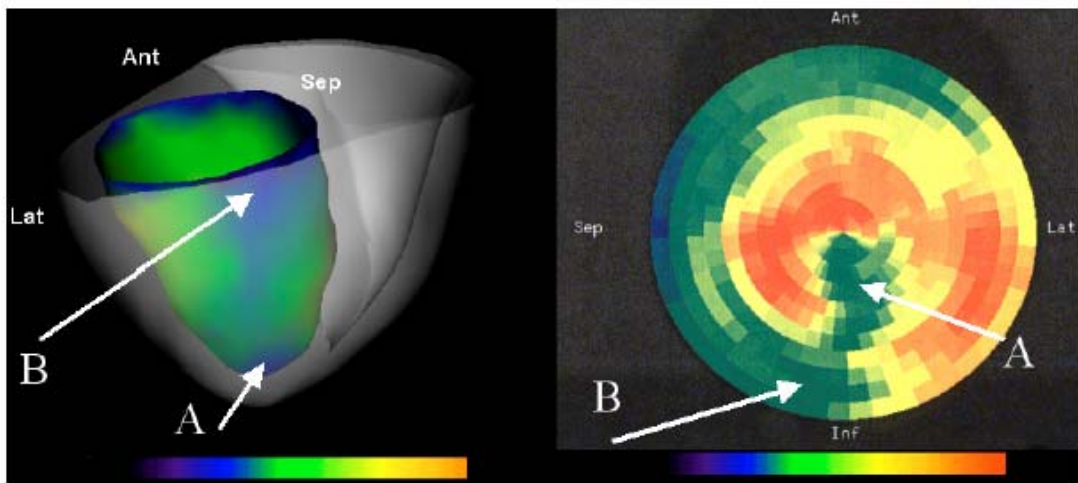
Haut. Cartographies 3-D de la captation du fluorodésoxyglucose (gauche) sur le modèle de cœur biventriculaire du patient E2. La représentation polaire réalisée manuellement de l'image TEP-FDG correspondante est présentée à droite. Bas: Cartographies 3-D des valeurs de densité de courant plaquées sur le modèle de cœur biventriculaire du patient E2. A droite : représentation polaire 2D réalisée de façon interactive à partir de la surface interne en 3-D. Les flèches indiquent des zones qui se correspondent.
